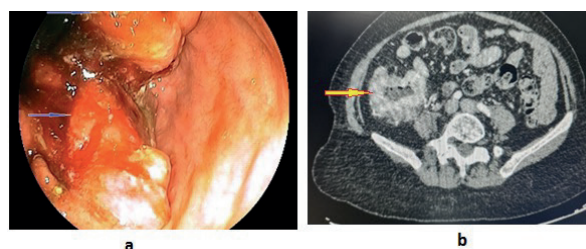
Colonoscopy image of CRC (a) and its computed tomography image (b).
